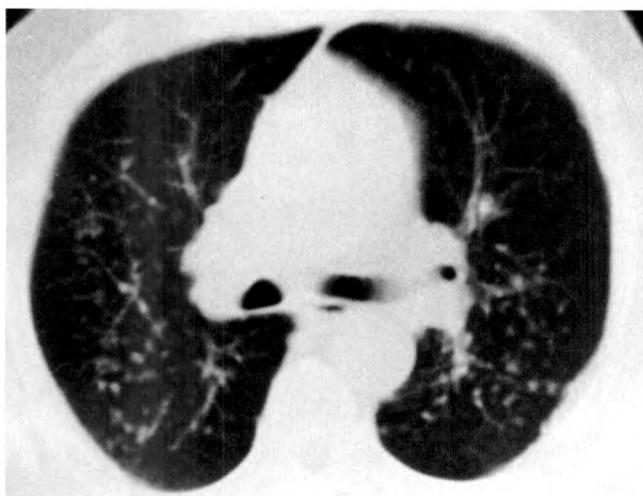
CT scan below carina in patient with silicosis shows nodules in middle interstitium with posterior predominance. Axial and peripheral interstitial compartments are normal.
